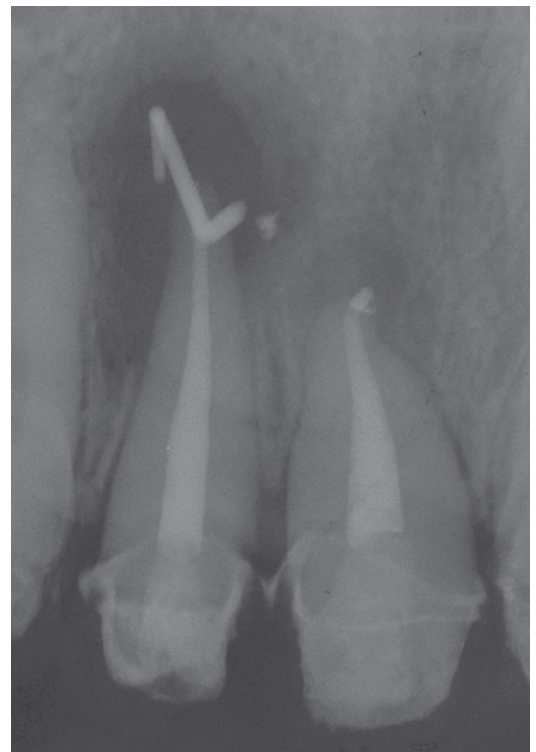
A radiograph with gutta percha cone tracing taken at one month after canal filling.
